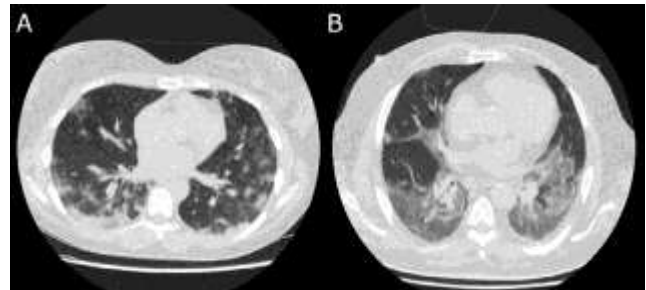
CO-RADS 5 .typical HRCT findings of multifocal peripheral subpleural GGOs & subpleural reticulations
